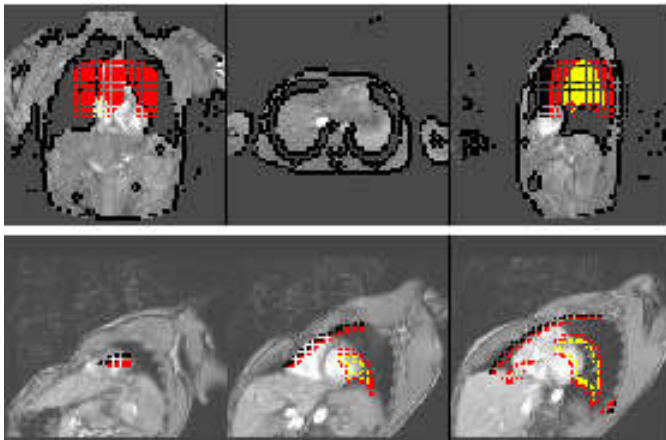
Two application examples of a deformable thorax model after fully automatically matching it to two thoracic MR image sets. The dotted boundary strips represent the expected location of the boundaries of the left lung, right lung, diaphragm and epicardial surfaces. The top row shows the model displayed on three orthogonal slices from a thorax scout view consisting of 27 slices. The bottom row displays the result of the direct application of the model matching procedure to a set of short-axis cardiac MR images, displayed on three slice levels in the image set. [Click on the images to activate the movies.](#)
